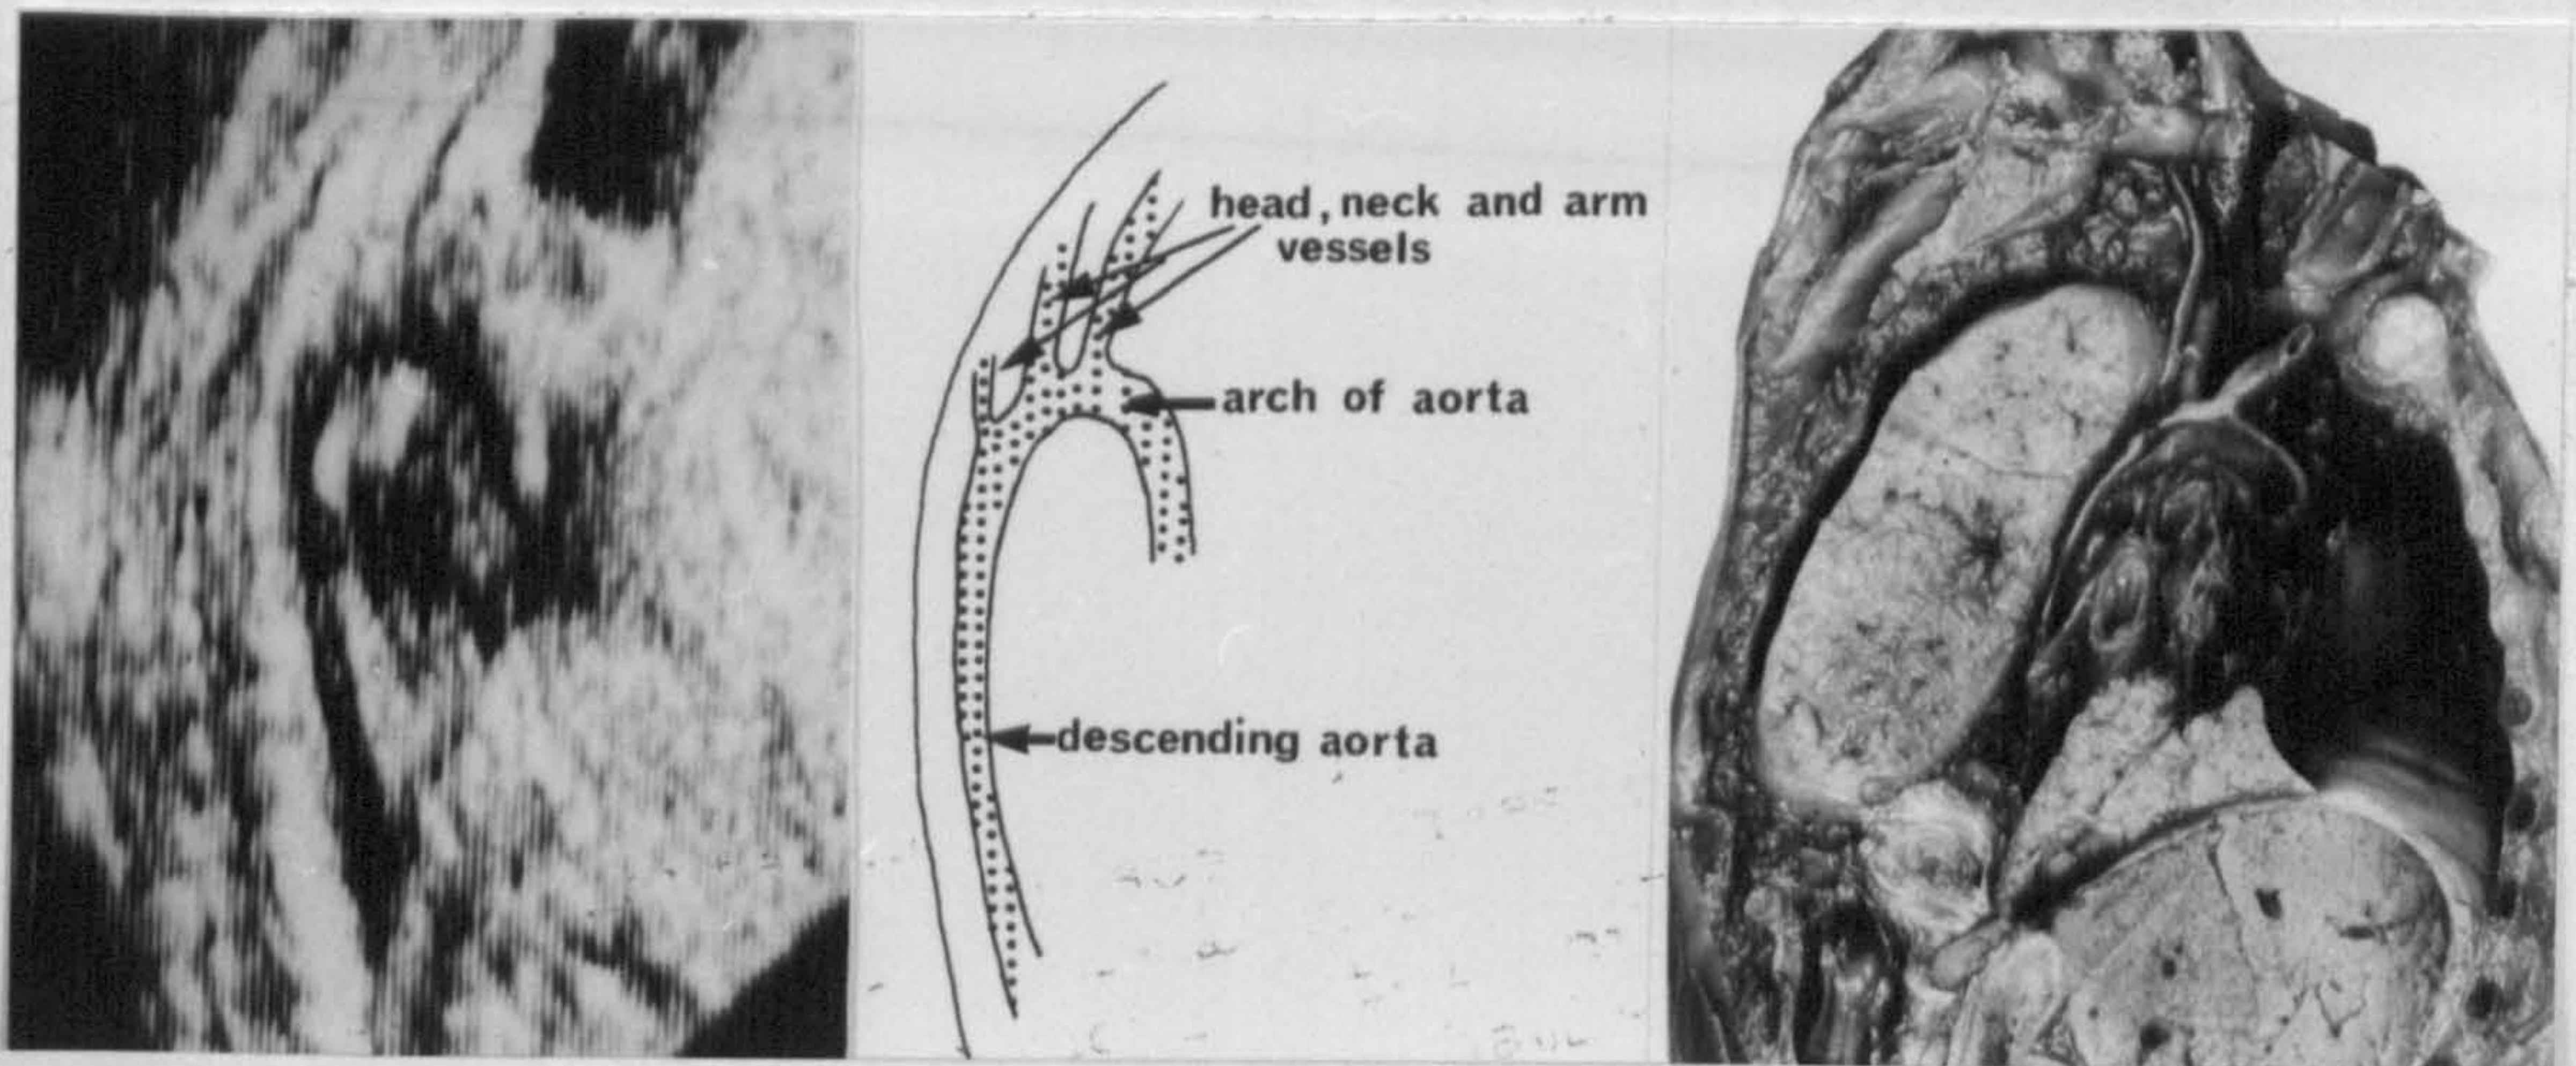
Aortic arch plane displayed echocardiographically and anatomically. The ascending, descending and arch of the aorta can be seen with head, neck and arm vessels arising from the arch.
